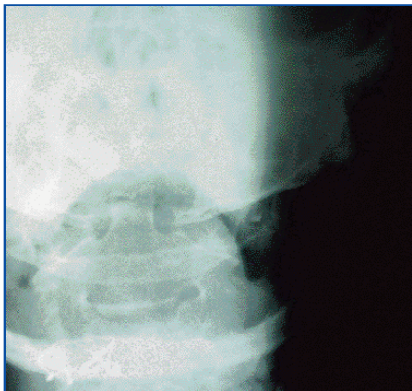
Anteroposterior x-ray.
